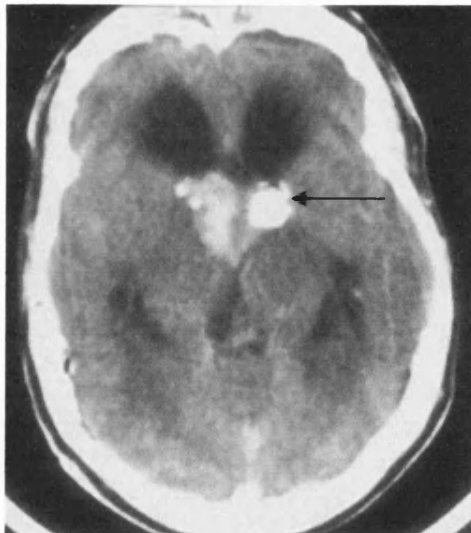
Figure ten – Giant cell astrocytoma (CT scan)
